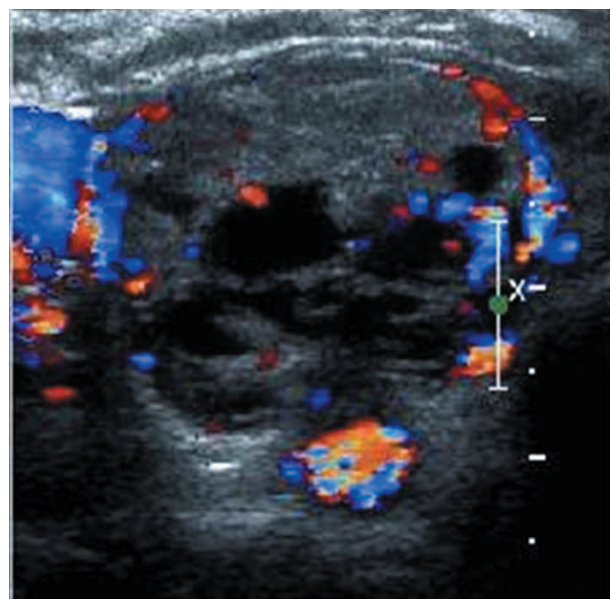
Neck ultrasonography color Doppler. Increased vascular flow inside the mass.
